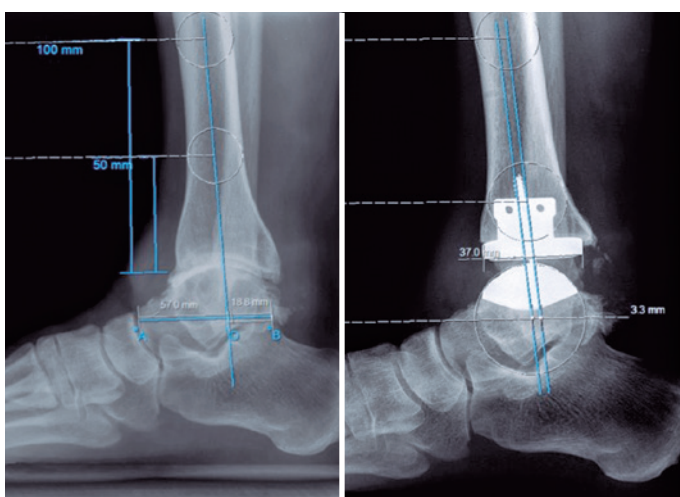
Lateral ankle radiographs showing the T-T ratio and the AP offset ratio.
